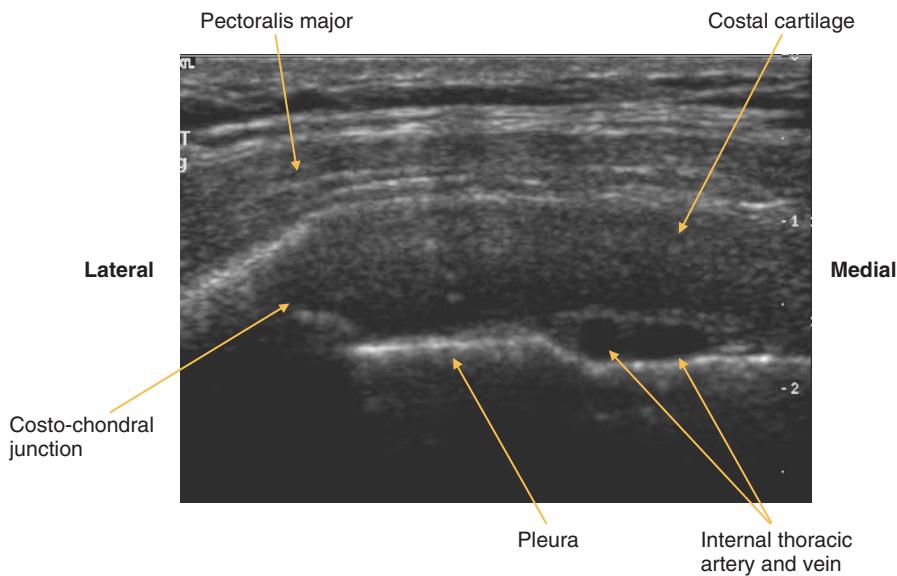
LS, chest wall parasternal
